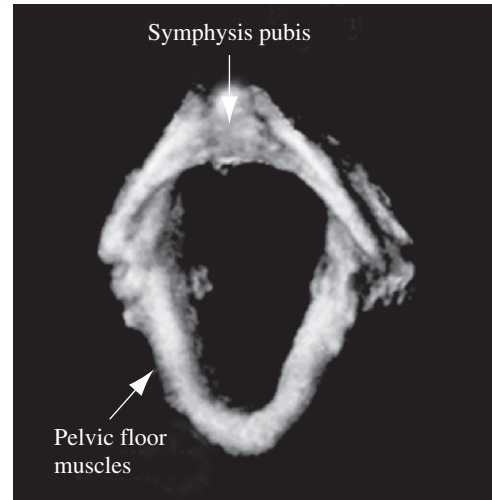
2. The pilot study of three-dimensional ultrasound visualisation. Ultrasound images of the pelvic floor in a normal 31-year-old woman were acquired using GE Voluson 730 Ultrasound System. The three-dimensional reconstruction and the segmentation of anatomic structures were performed using GE 4D View (V 4.1).
